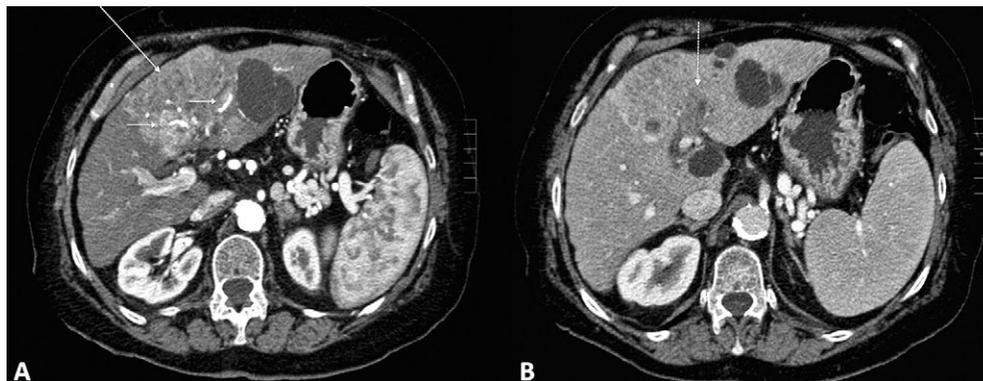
CT scans of the abdomen performed at diagnosis. A) Arterial phase shows a large enhancing “spread like” hepatocellular carcinoma (HCC) located at IV hepatic segment (arrow), with marked hypertrophy of the feeding arteries (small arrows). B) Hepatic venous phase and delayed phase CT scan shows hypodensity of lesion to liver parenchyma with thrombosis of the left portal vein branch (dotted line).
